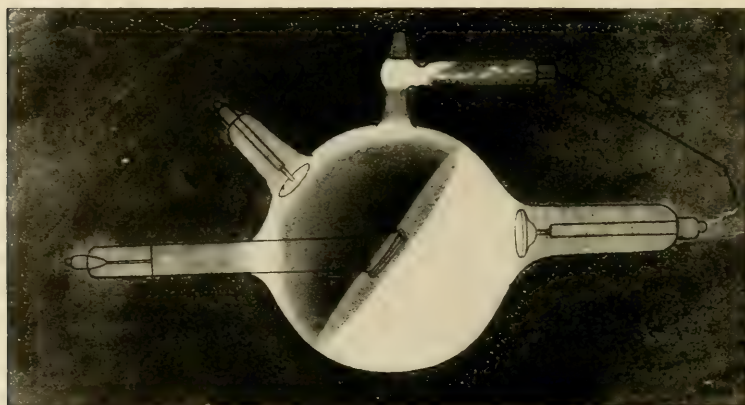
X-ray tube properly lit up.
